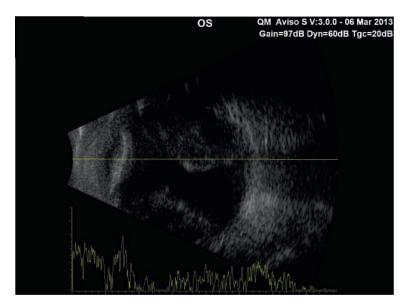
B-scan ultrasound image of a patient with suprachoroidal hemorrhage post-cataract surgery. Notice the domeshaped appearance and central apposition of detached choroid. The suprachoroidal space is filled with moderate amplitude spikes suggestive of suprachoroidal hemorrhage (courtesy of Dr. A. Al-Hinai).
